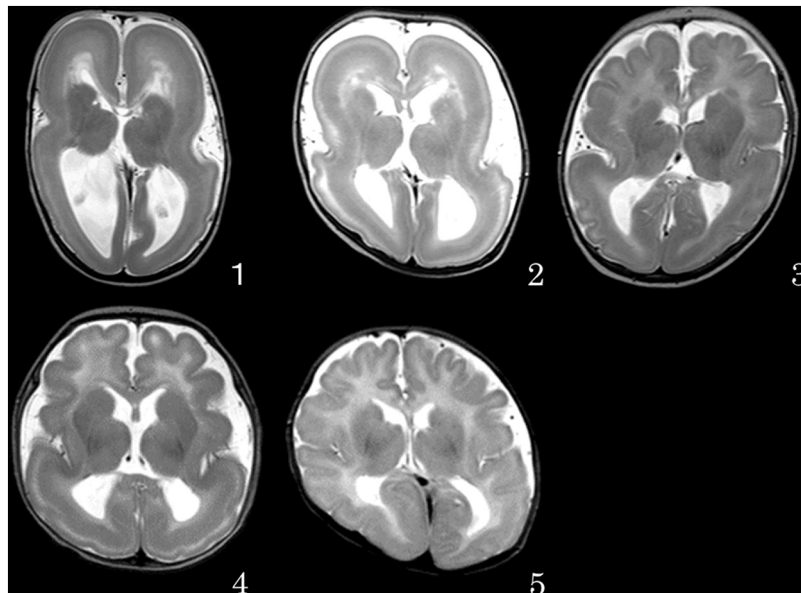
Representative brain magnetic resonance imaging (MRI) findings in T2-weighted images. Each number indicates patient number in Table 1.
